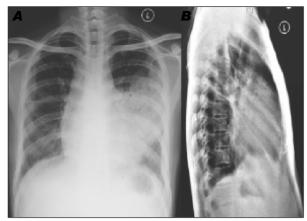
Chest radiograph (postero-anterior) (A) and lateral (B) views showing cardiomegaly and lingular consolidation
